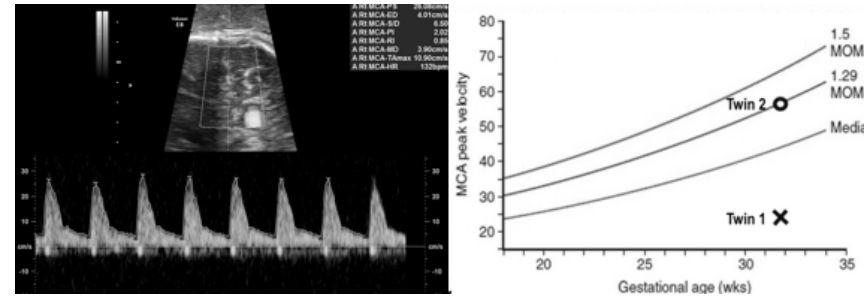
a) MCA doppler of Twin 1. MCA PSV 26cm/s and 0.56 MoM suggestive of polycythaemia b) Plotted MCA PSV of Twin 1 (cross) and Twin 2 (circle) at 32 weeks
